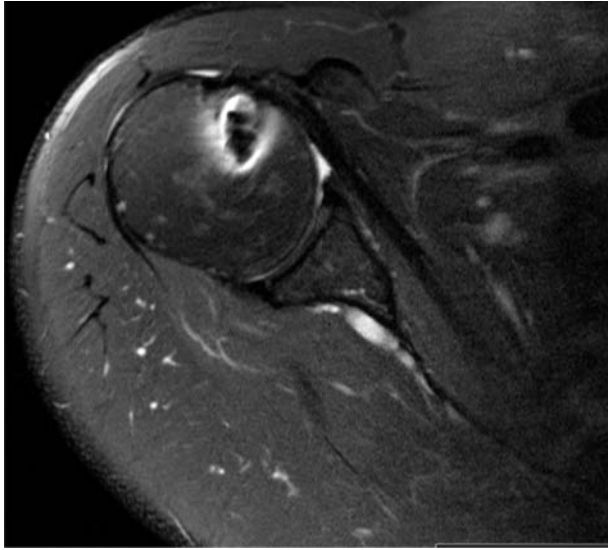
Postoperative MRI in the axial plane showing an intact subscapularis tendon repair.
